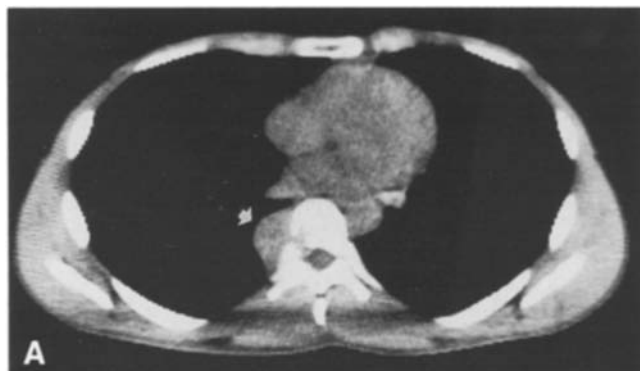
Extra adrenal malignant pheo. A CT scan of the lower chest showing a right paraspinal mass in the posterior mediastinum, characterized by homogeneous density similar to that of soft tissues, and sharp borders (*arrow*). The eight dorsal vertebra is eroded with no apparent intra spinal involvement. B ^{131}I -MIBG scan. Posterior view of the chest showing an area of abnormal uptake. C The region of interest selected over the focus of abnormal MIBG uptake is superimposed on the bone scan and it appears localized in the right side of spine (eight dorsal vertebra)
